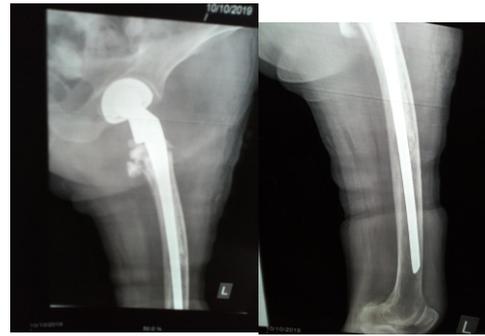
Showing plain radiograph of long stem cemented bipolar hemiarthroplasty Fig. 2 and 3. Showing plain radiograph
